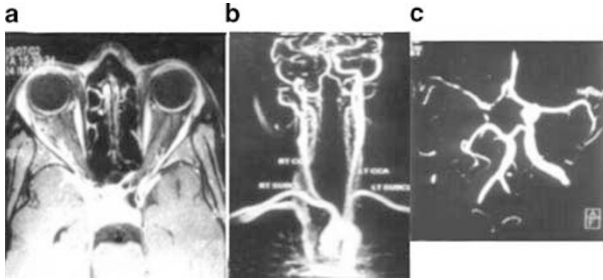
(a) Gadolinium enhanced MRI showing thickening and near total occlusion of distal right internal carotid artery. (b) MR angiography showing narrowing of the right internal carotid artery and external carotid artery. There was no evidence of dissection. (c) MR angiography showing narrowing of right anterior cerebral artery and middle cerebral artery.
